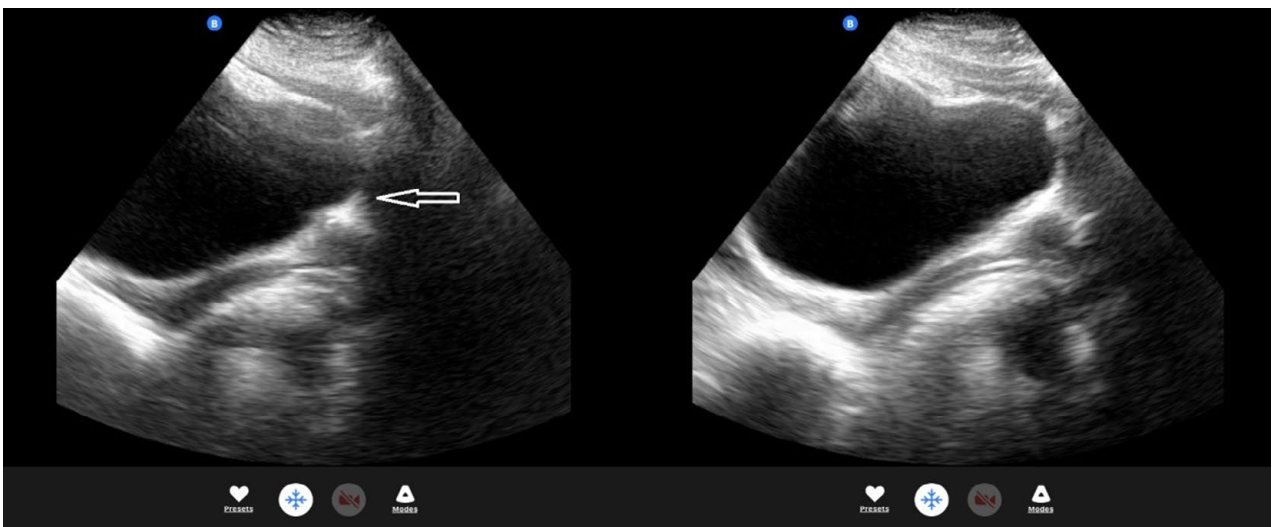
Longitudinal image showing pubic bone shadow on pelvic ultrasound.
